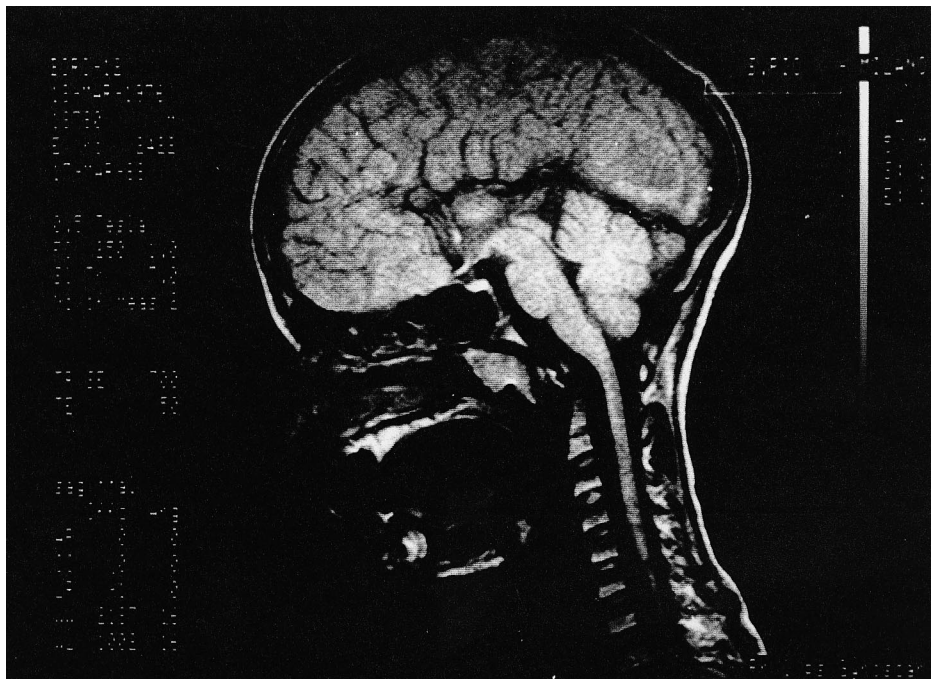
Magnetic resonance image of R.B.'s brain in midsagittal plane.
